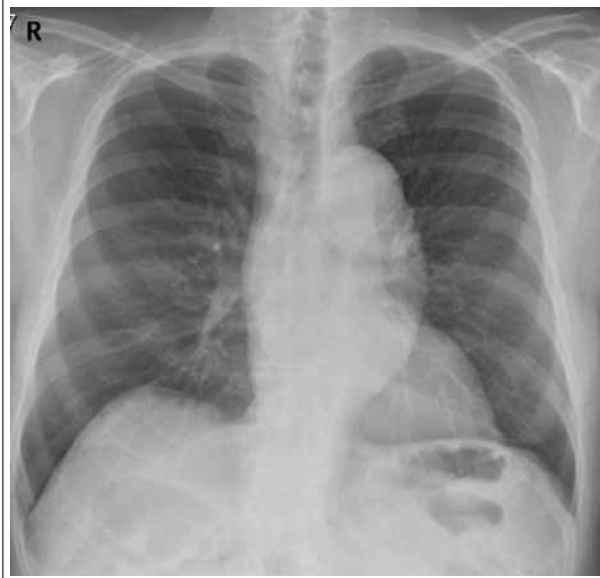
Chest X-ray in 2008
